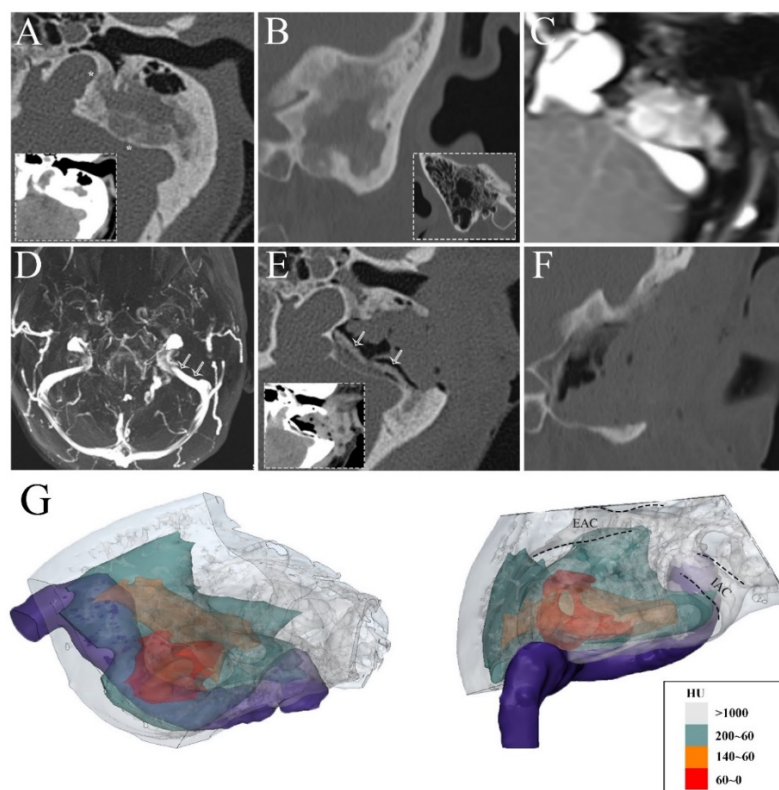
(A) The high-resolution temporal bone computed tomography (CT) showcasing a diffusive sign of radiolucent ground-glass matrix confined to the posterior portion of the mastoid cavity. The heterogenous lytic change of the bone lesion with a tendency of cystic development characterized by less-defined margins is detected. White asterisk indicates FD compression/involvement of sigmoid sinus plate/jugular bulb region. (B) The Sagittal CT plane displays FD possessing the entirety of the mastoid cavity and change of mastoid pneumatization. (C) Contrast-enhanced magnetic resonance (MR) demonstrates enhancement of mass lesion with vague signs of fluid-fluid levels compressing the upper curve of the sigmoid sinus. (D) 2D Time-Of-Flight MR showcasing a notch-like defect due to a roughly 15% diameter decrease of the sigmoid sinus caused by the withdrawal of the sigmoid plate secondary to FD compression (white arrows). (E) and (F) Postoperative CT scan took 5 hours after surgical intervention. The bone lesions within the mastoid cavity with were radically resected. The sigmoid sinus plate was reconstructed using the normal autologous cortical bone of the mastoid (white arrows). (G) The three-dimensional planar reconstruction of the high-resolution temporal bone computed tomography (CT). The characteristics of the bone mineral density of the lesion are displayed using a different range of the Hounsfield unit (HU). EAC indicates external auditory canal; IAC indicates internal acoustic canal.
